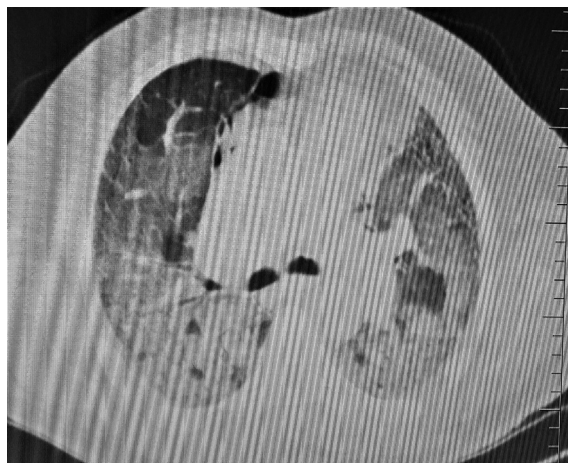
CT scan of chest showing 'crazy paving' appearance.
